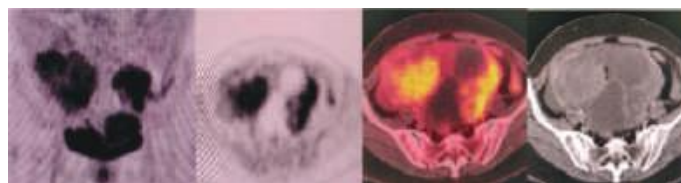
PET-CT in B/I Adnexal Mass – PET reveals metabolically active bilateral pelvic lesions and CT can localized them to be adnexal in origin
